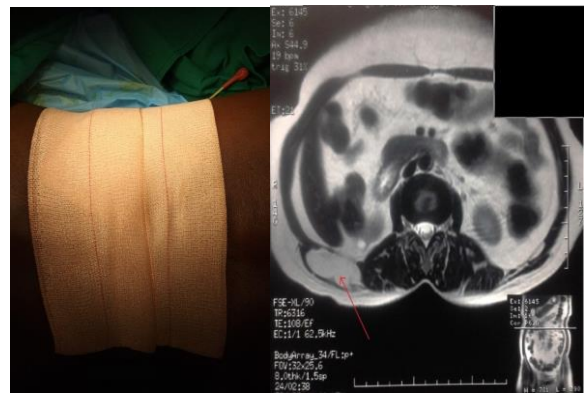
MRI showing hernia content.
